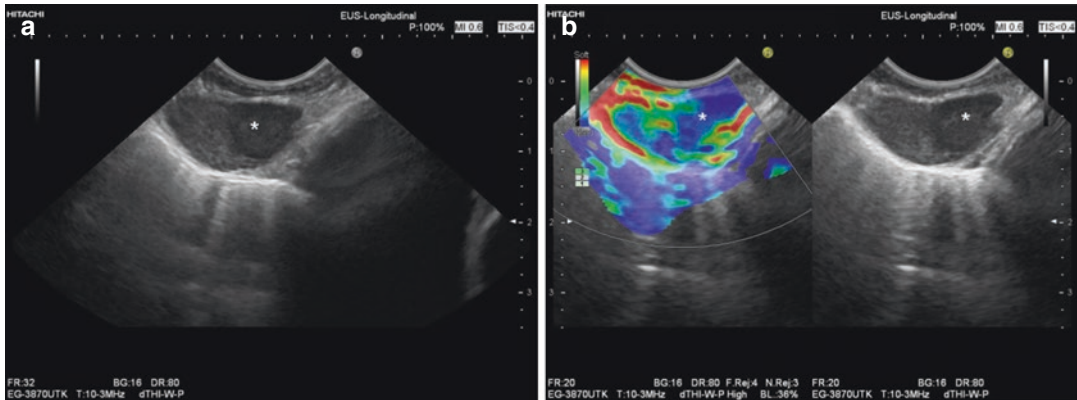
Large suspicious mediastinal lymph nodes (Station 7/8) in a 58-year-old female patient who had undergone a nephrectomy for renal cell cancer 2 years prior (a). EUS-elastography shows heterogeneous elasticity with soft central parts and harder peripheral parts (b). Contrast-enhanced endoscopic ultrasound reveals central necrosis (c). To avoid a false-negative finding and infection, only the peripheral parts of the lesion were targeted by EUS-FNA (22-gauge aspiration needle)
